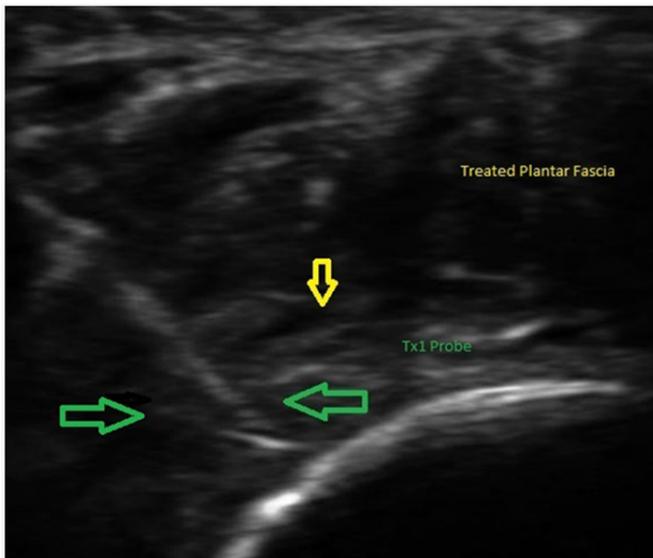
TX1 probe inserted into the lesion under ultrasonic visualization.
